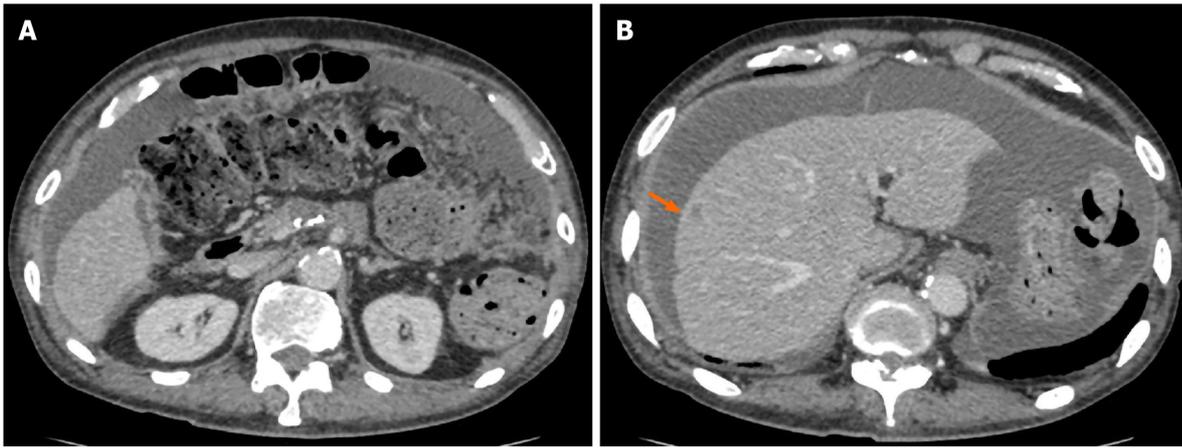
Computed tomography obtained 5 mo after surgery. An ascites associated with cancerous peritonitis and liver metastasis (arrow) was observed.
